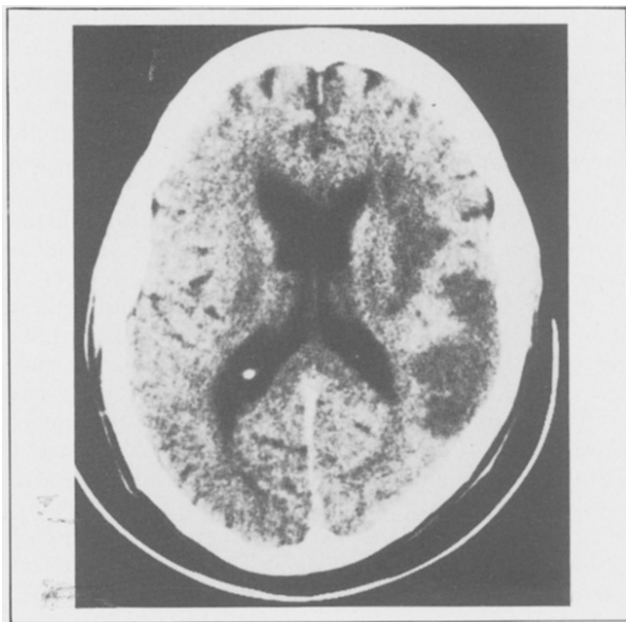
CT scan of Case 6 demonstrates right-sided lesions involving the insular region, anterior and posterior temporal lobe, and anterior parietal lobe.
